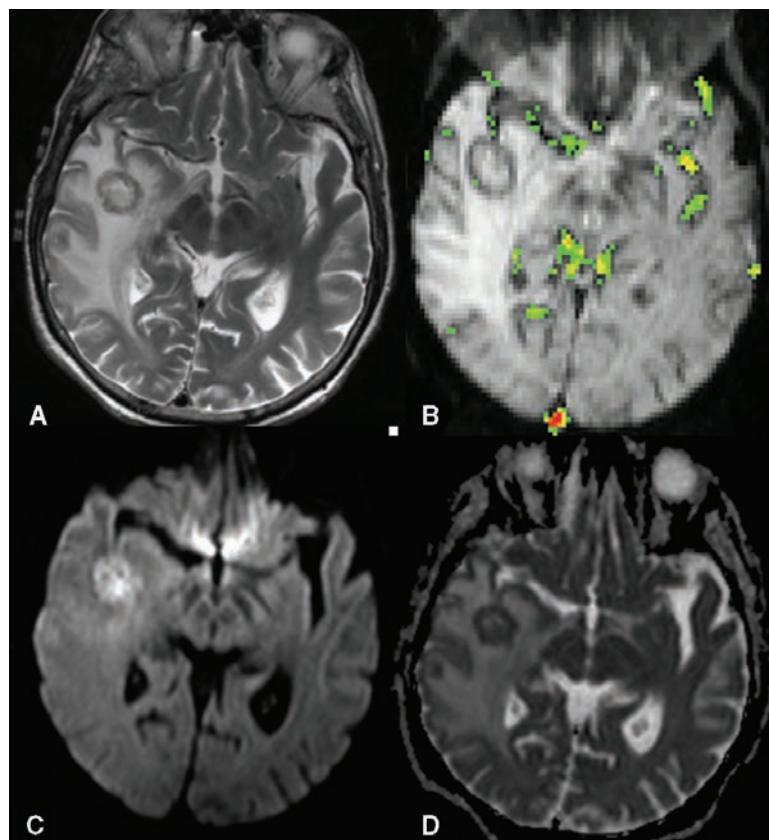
A 45 year-old-woman with a bacterial abscess. (A) Axial T2-weighted image demonstrates substantial vasogenic edema surrounding the mass but minimal mass effect. (B) Gradient-echo axial DSC MRI with rCBV color overlay demonstrates reduced rCBV within the lesion. There may be a thin rim with very minimally increased rCBV immediately adjacent to the enhancing edge of the abscess capsule. (C/D) Diffusion-weighted imaging with corresponding ADC map demonstrates some diffusion restriction seen in bacterial abscesses. Abbreviations: DSC MRI, dynamic susceptibility contrast MRI; rCBV, relative cerebral blood volume; ADC, apparent diffusion coefficient.
